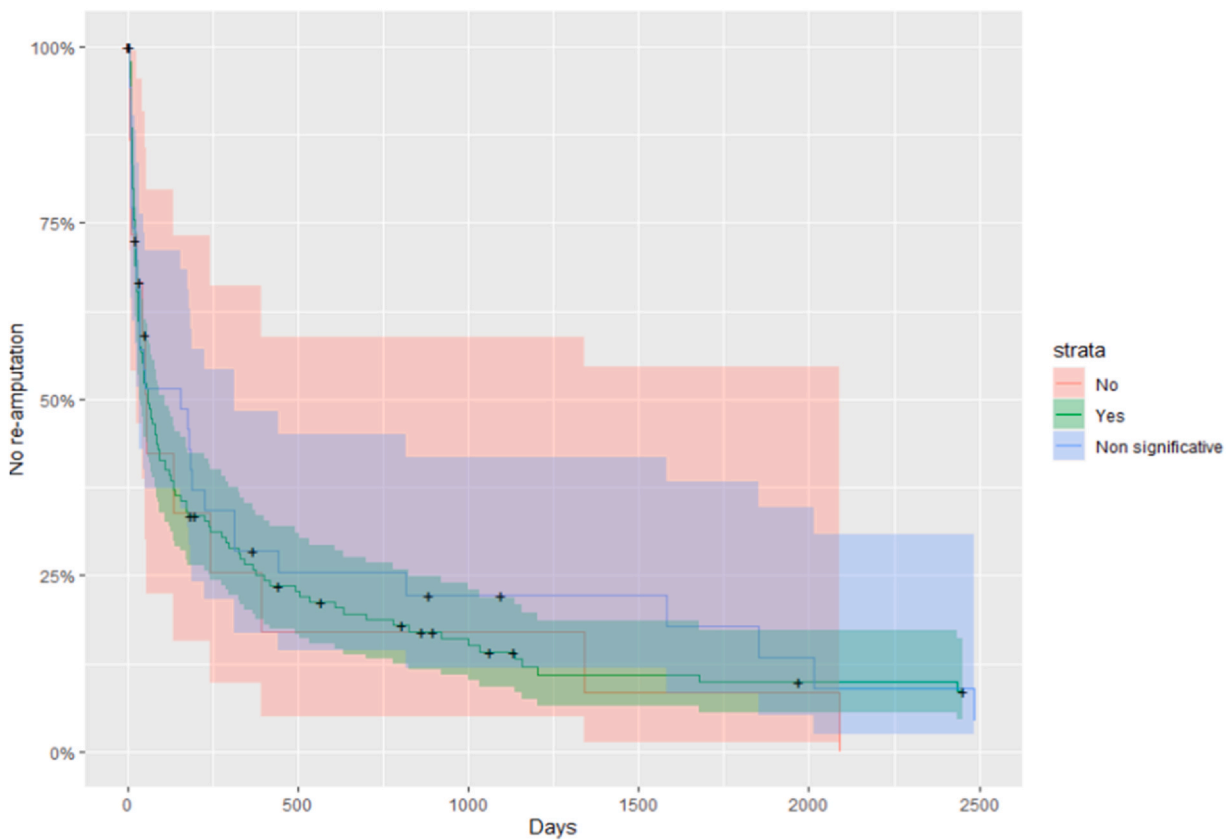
Kaplan Meier curve for survival between amputations and arterial occlusion in doppler ultrasound.
